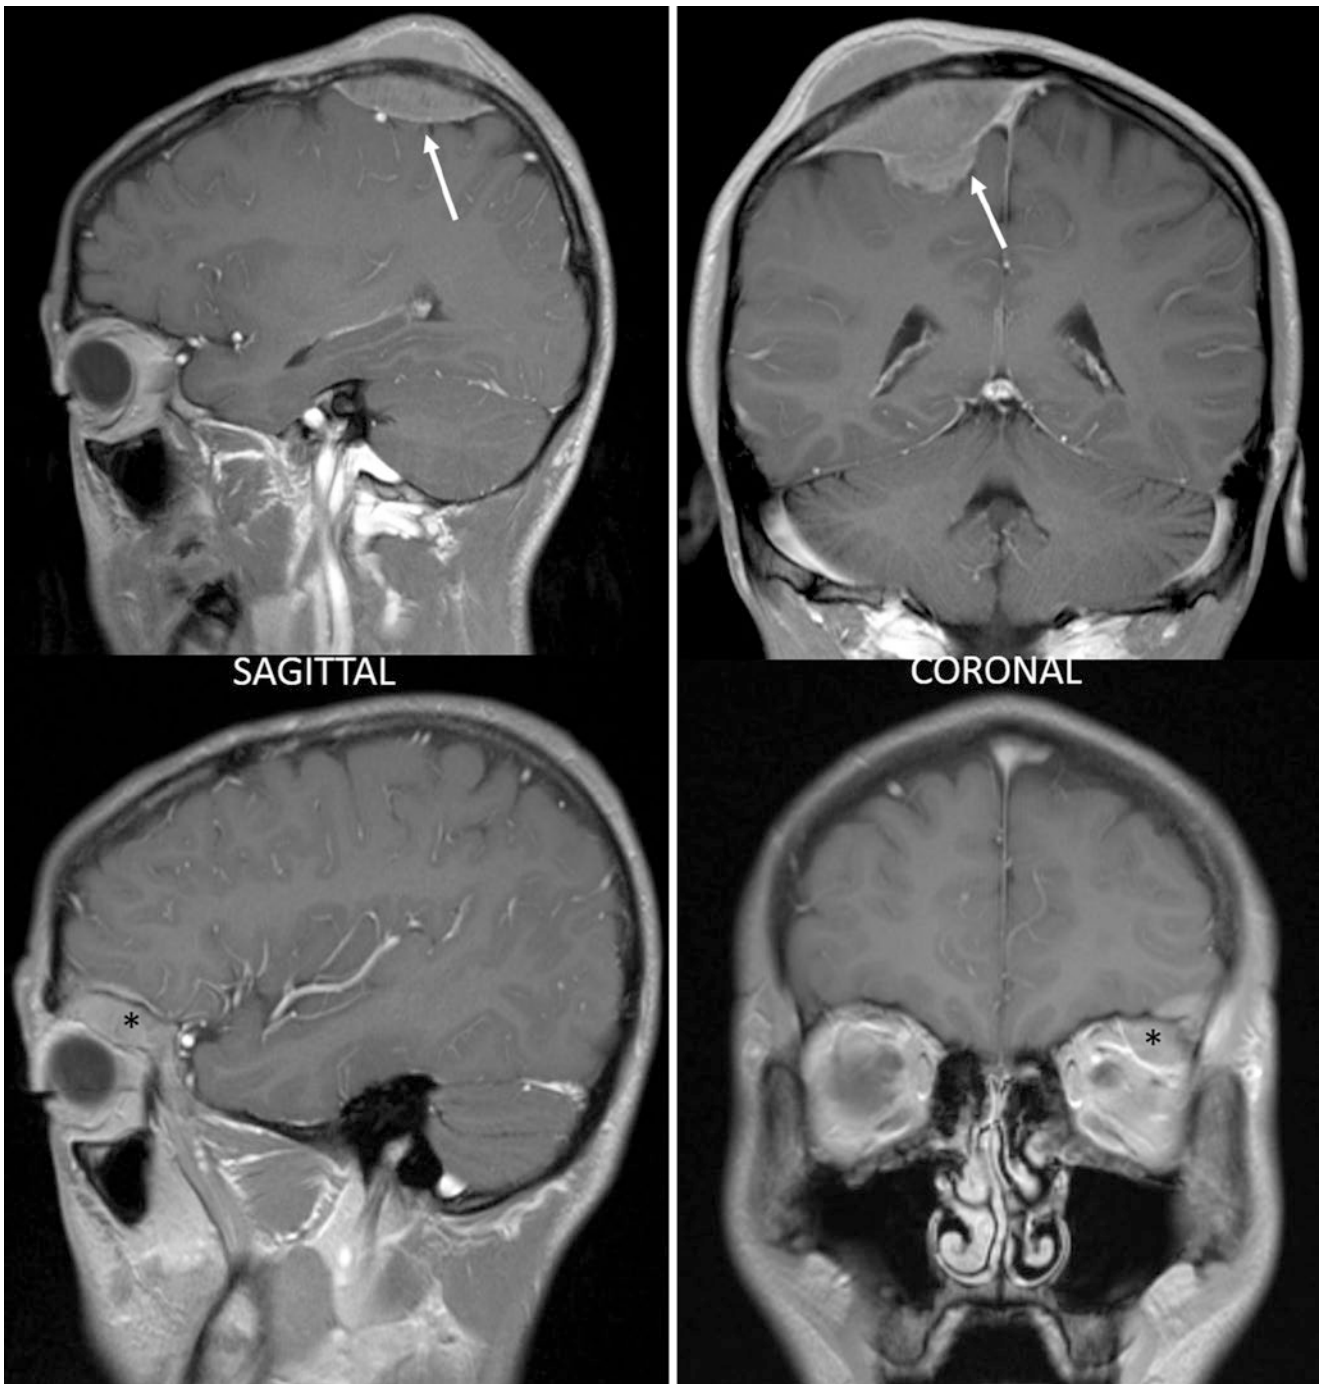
MRI T1w + C showing metastases to the skull (white arrow) and left orbital roof (*) with large extra-osseous soft tissue components
